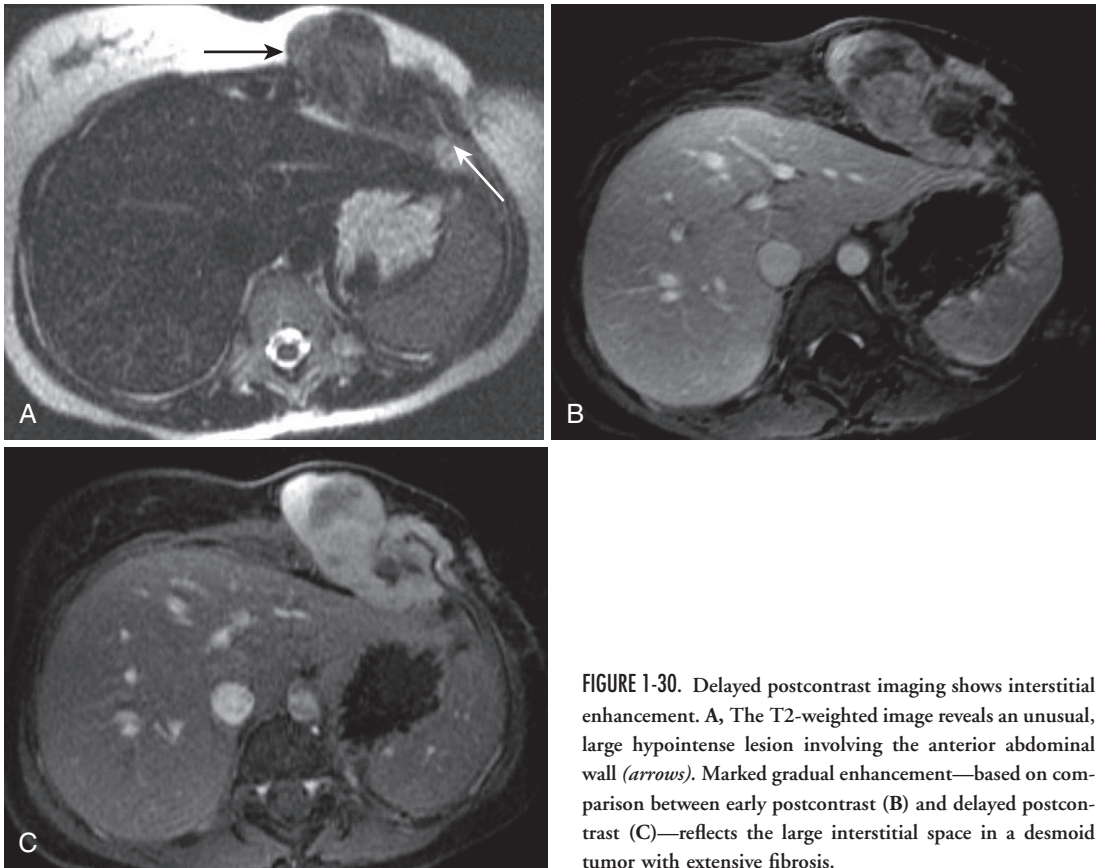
Delayed postcontrast imaging shows interstitial enhancement. A, The T2-weighted image reveals an unusual, large hypointense lesion involving the anterior abdominal wall (*arrows*). Marked gradual enhancement—based on comparison between early postcontrast (B) and delayed postcontrast (C)—reflects the large interstitial space in a desmoid tumor with extensive fibrosis.
